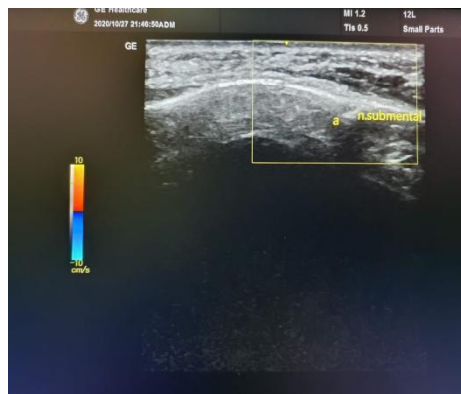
Patient's Ultrasonogram submental nerve before injection.
